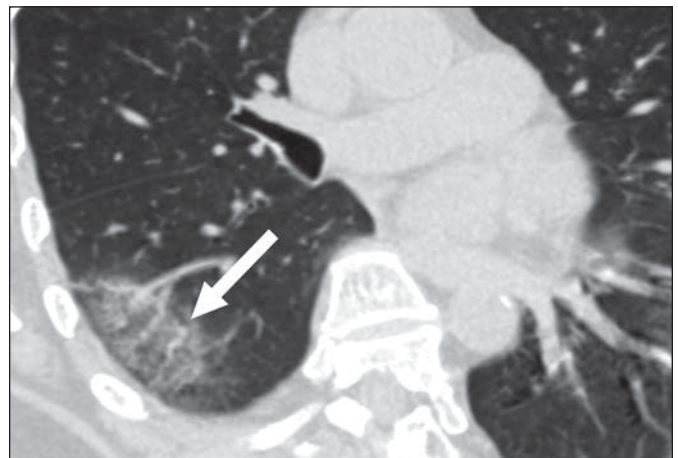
61-year-old woman with coronavirus disease (COVID-19). Oblique transverse CT image shows ground-glass opacities with vascular enlargement (*arrow*).
